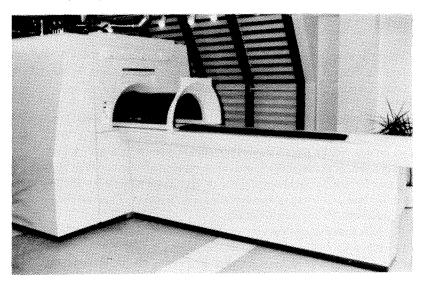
Typical clinical MRI installation.
